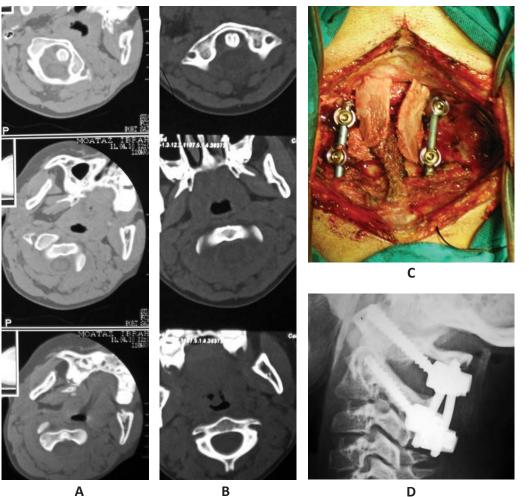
Case number 7, 8 years boy with sports injury. A; Axial CT showing type-I clockwise recurrent AARF. B; Axial CT showing reduction of the AARF. C; Operative image showing screws and rod in situ with iliac crest grafting. D; Postoperative plain radiograph showing adequate screw purchase.
